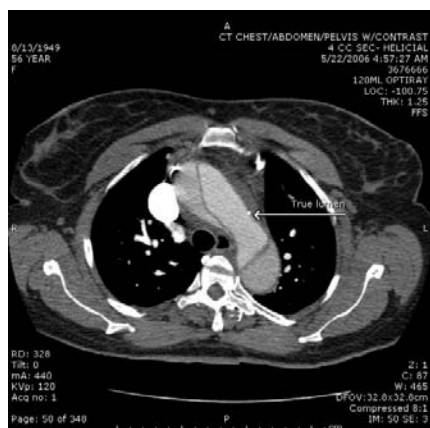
Contrast-enhanced computed tomographic scan of the chest revealing a proximal aortic dissection involving the aortic arch and showing the true and false lumen. www.medreviews.com
